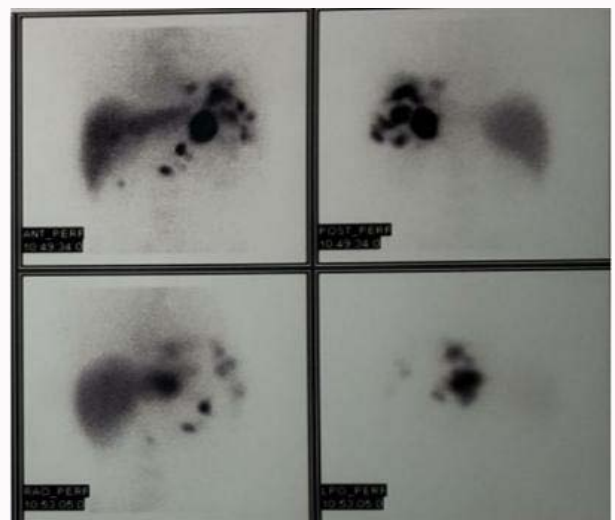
Tc-99m erythrocyte scintigraphy image showing accessory splenic tissue.
